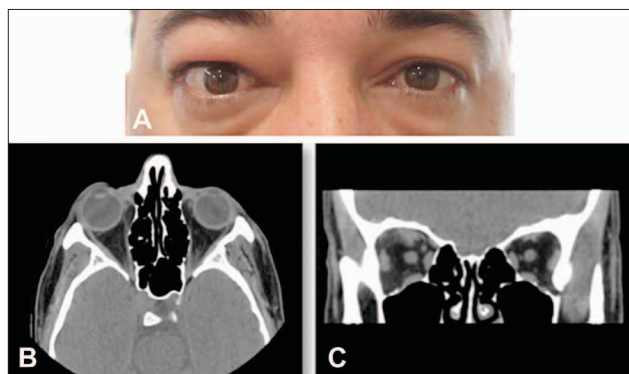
40-year-old man OCT, with active GO, before treatment with tocilizumab (A). Orbit CT shows right eye proptosis (B), as well as thickening of the right periorbital soft tissues and of the superior rectus muscle (C).
